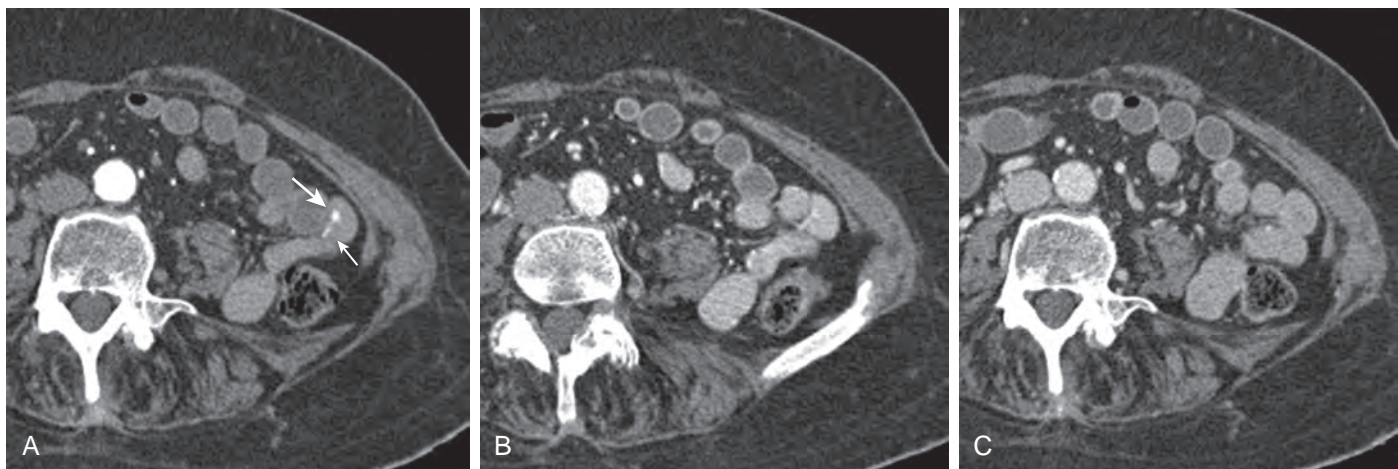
Dieulafoy lesion. A 58-year-old man with hematochezia. Arterial (A), enteric (B), and delayed (C) phase axial images from a multiphase CTE study demonstrate a small nodular area of enhancement in the distal jejunum visible only on the arterial phase (large arrow). Adjacent linear collection of contrast material (small arrow) may represent active bleeding. (From Huprich J, Barlow J, Hansel S, et al: Multiphase CT enterography of small bowel vascular lesions. *AJR* 201:65–72, 2013.)
